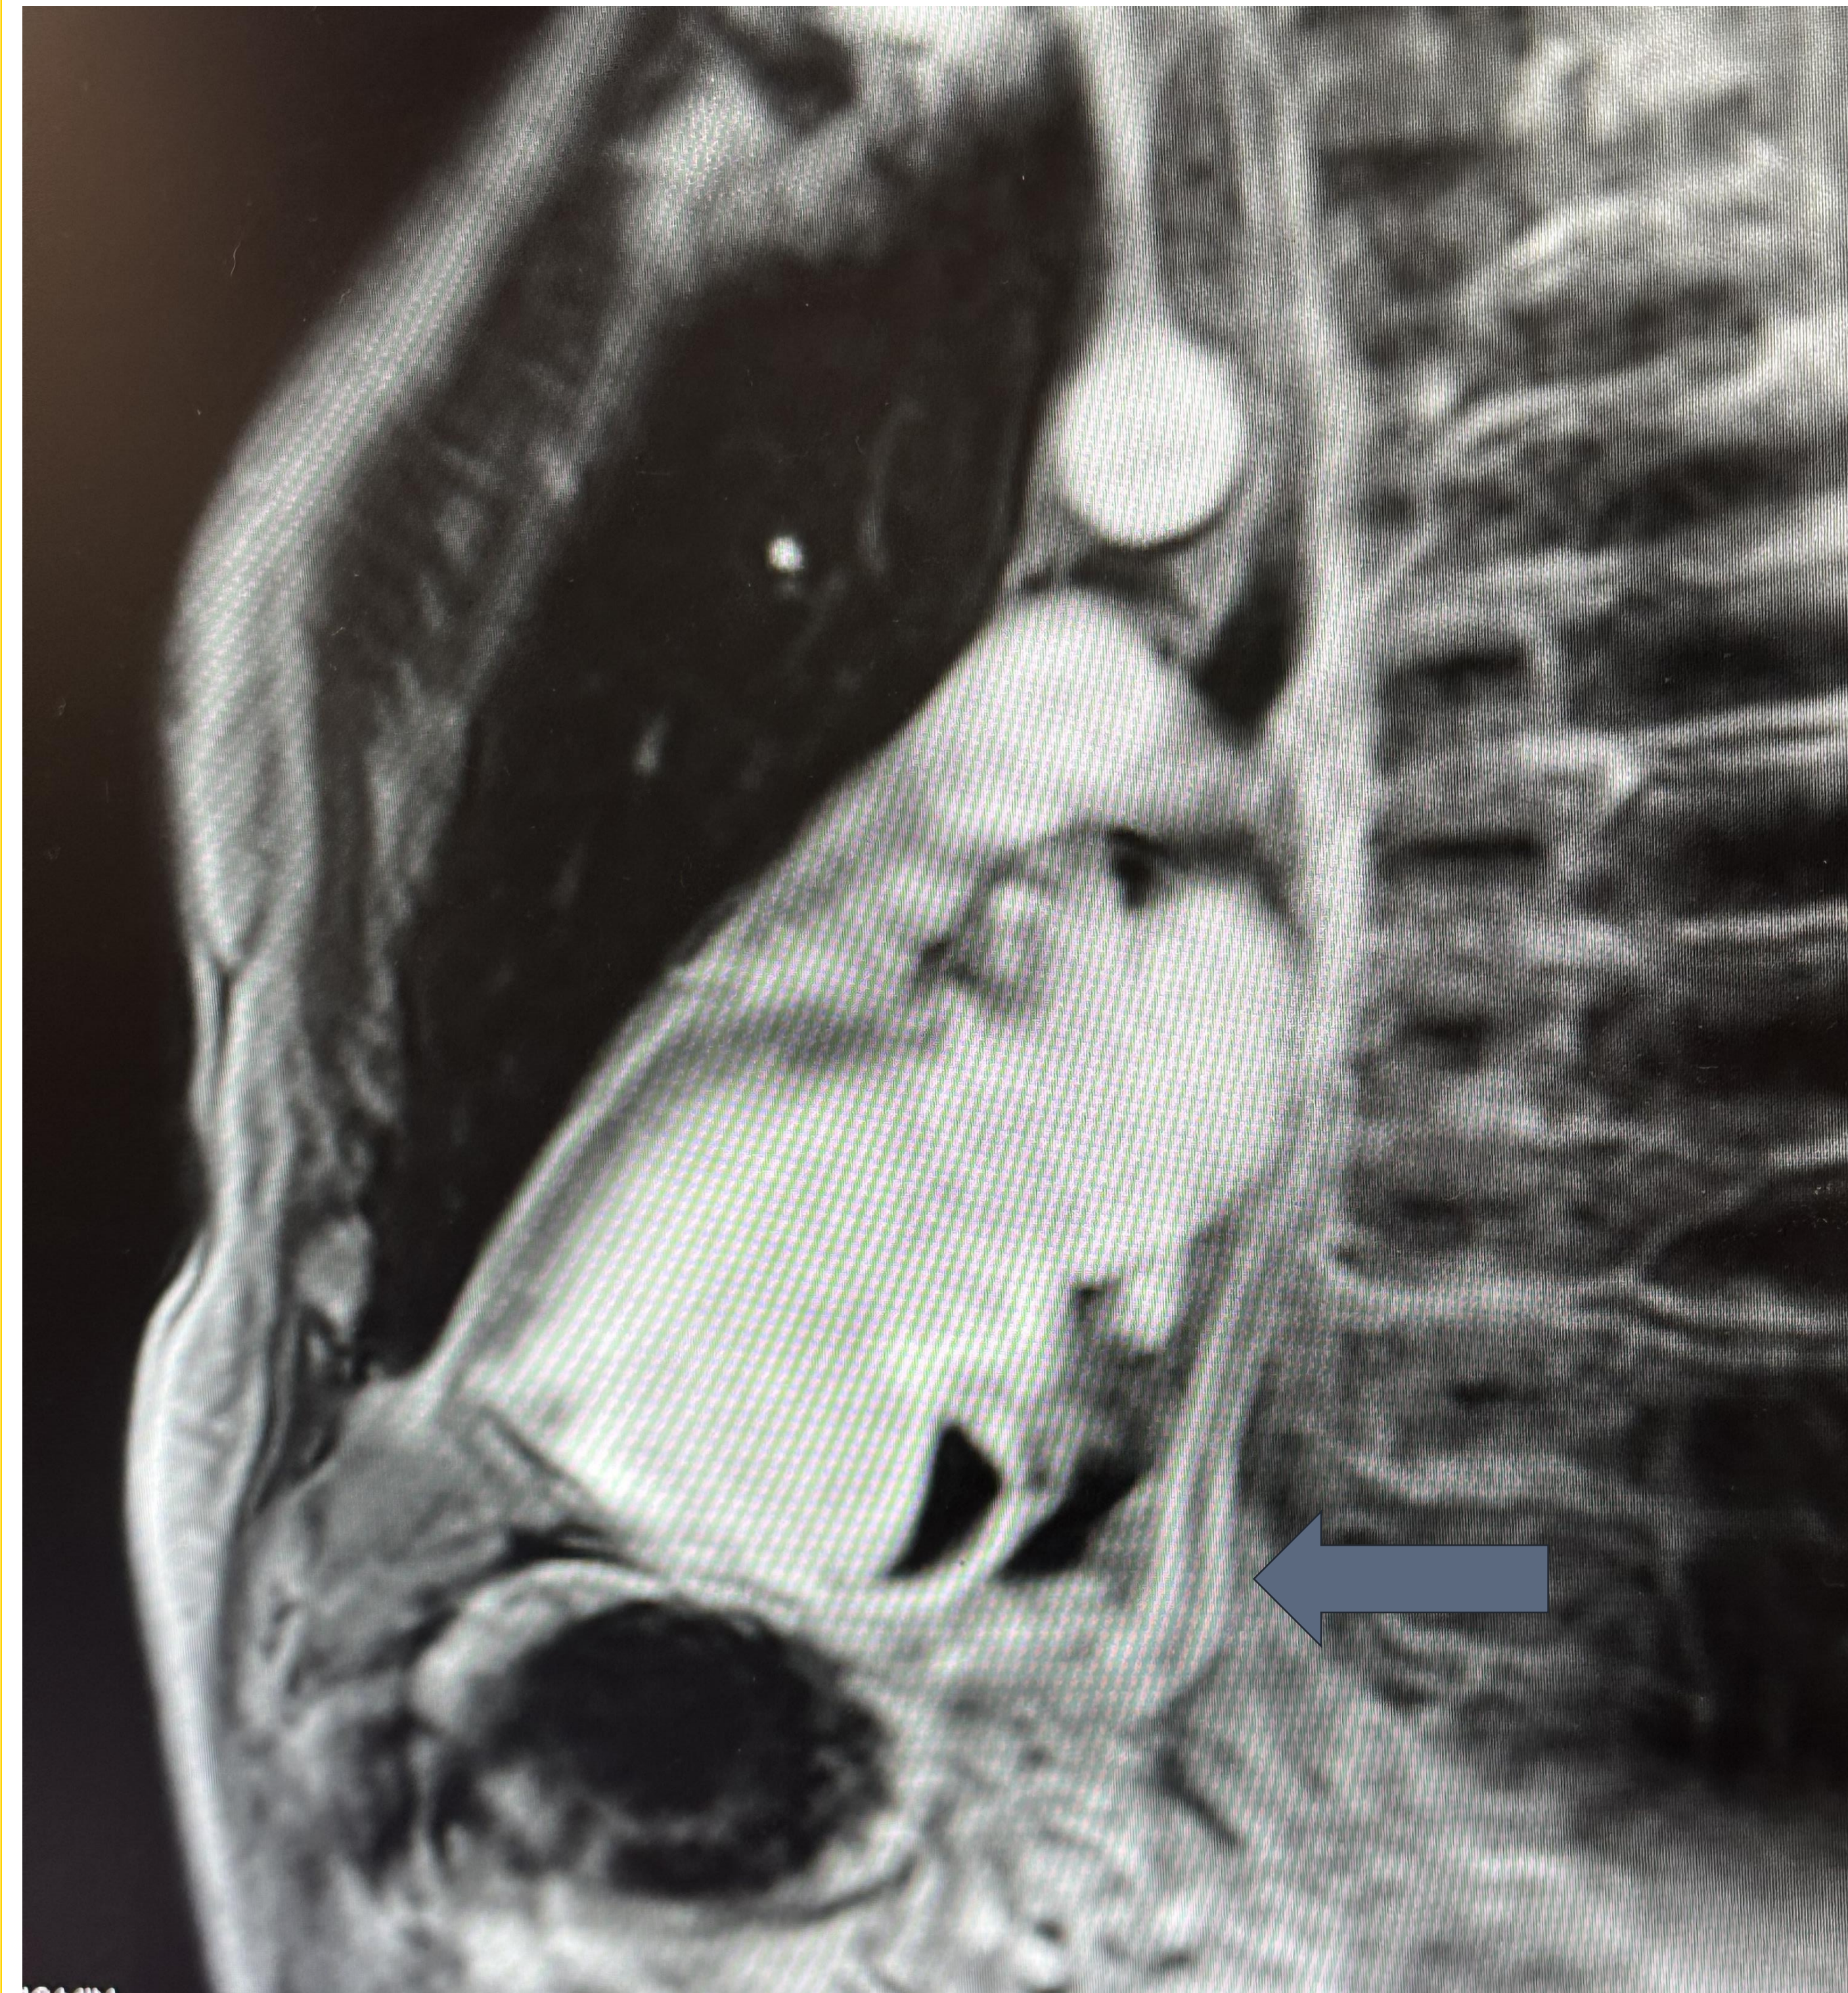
Mid to basal inferior segment aneurysm with a Crescent-shaped thrombus as seen on Cardiac MRI (arrow)
